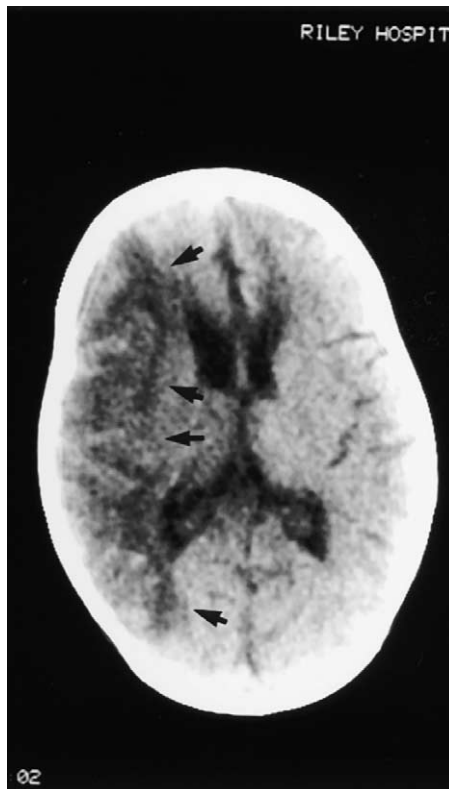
An 8-month-old girl with bacterial meningitis and sudden-onset left-sided hemiparesis and seizures. Axial head CT without contrast shows a large right middle cerebral artery territory ischemic infarct (arrows).
